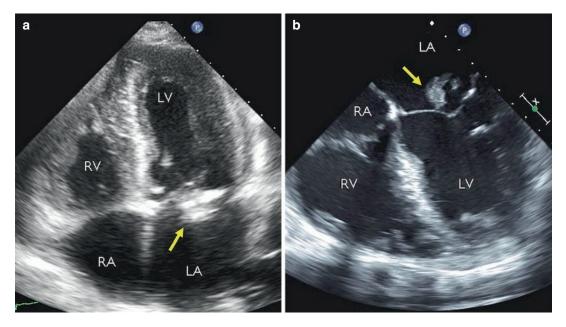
Representative images acquired by transthoracic echocardiography (TTE; a) and transesophageal echocardiography (TEE; b) in the same patient with mitral valve endocarditis (arrowhead points to bacterial vegetation
